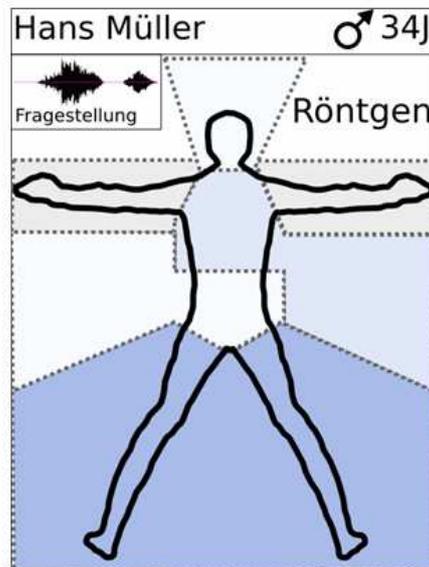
PDA sample screen managed by the nurse after the doctor submits an x-ray request.
